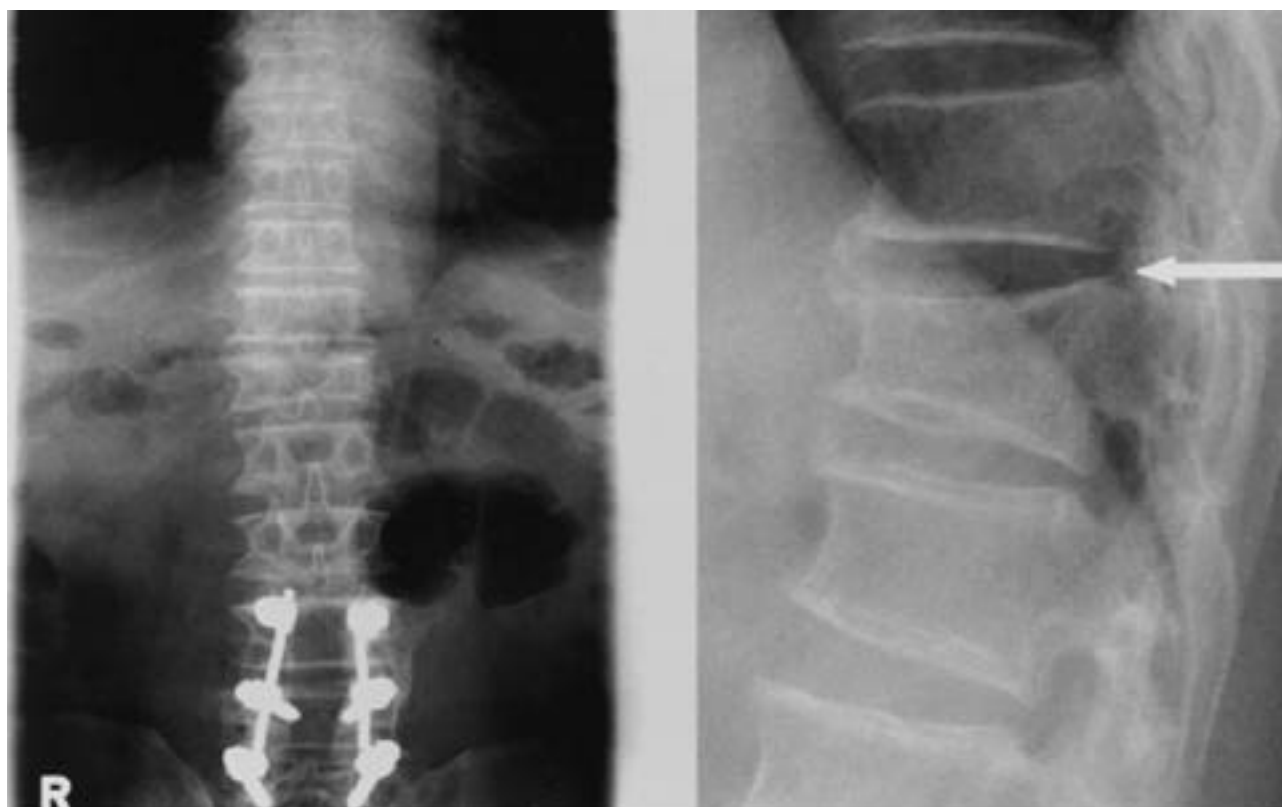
Preoperative anteroposterior & lateral radiographs shows a compression fracture of the body of T12 and triangular shaped mass are protruded into the spinal canal at T10-11, T11-12 level (case 1).
